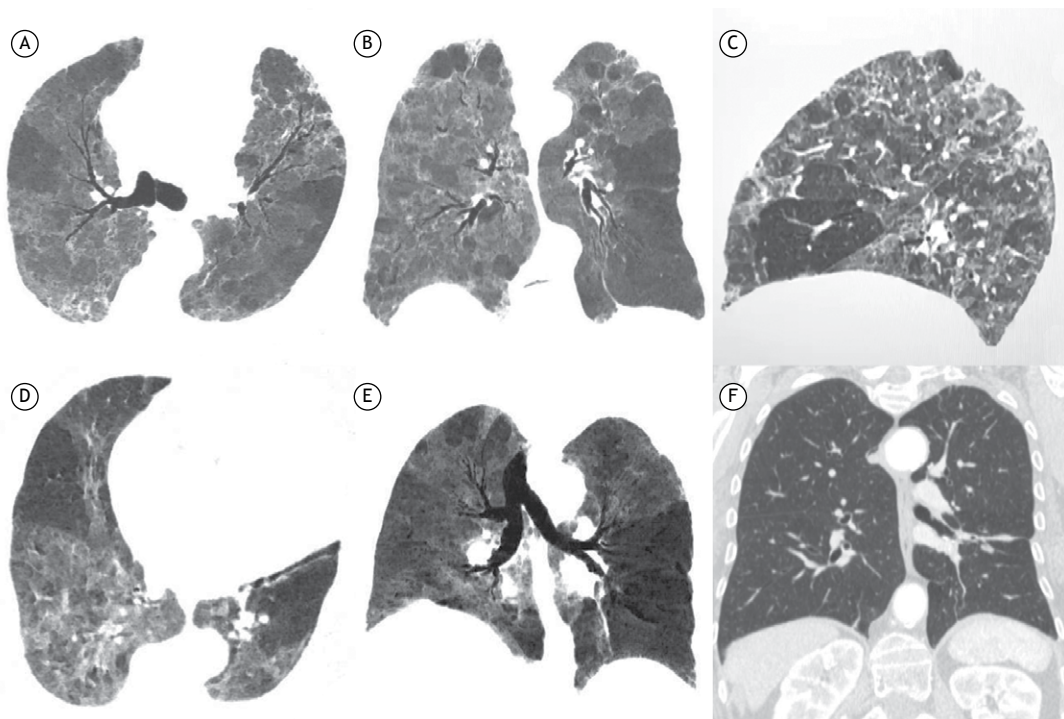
Axial, coronal, and sagittal chest CT reconstructions (in A, B, and C, respectively) showing areas of varying attenuation within the lung parenchyma. In D and E, expiratory CT scans showing air trapping. In F, chest CT scan performed ten months earlier and showing normal lung parenchyma, the exception being a small band-like opacity in the middle third of the left lung.
